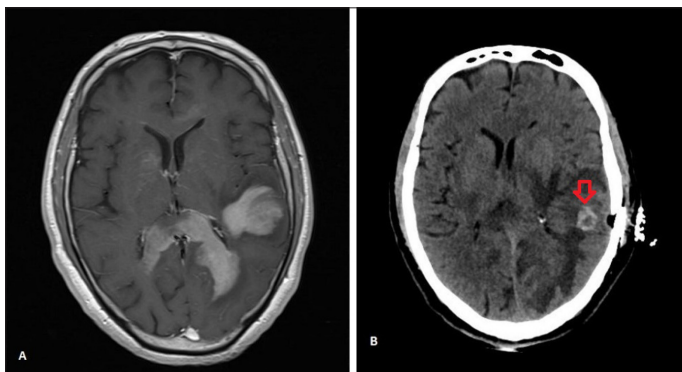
(A) The appearance of the lesions as hyperintense in contrast-enhanced T1 axial MRI, (B) Hematoma appearance in the biopsy area in postoperative early control cranial CT.
